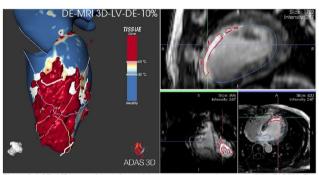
LGE- MRI map of the left ventricle, next to a three-plane view of the DICOM. The tissue is displayed in blue for non-enhanced tissue (healthy), in red for highly enhanced tissue (core), and from light blue to orange represents the grey-area tissue.
